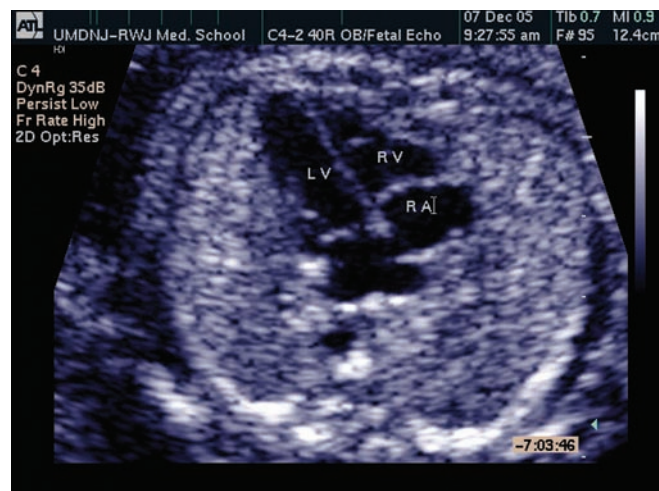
Apical four-chamber view of the fetal heart, demonstrating left atrium and left ventricle (LV) and right atrium and ventricle (RA, RV).
